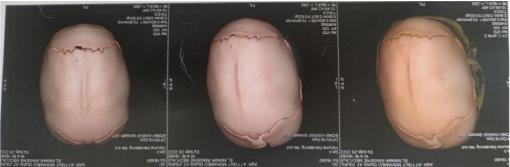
Cerebral CT scan showing scaphocephaly
